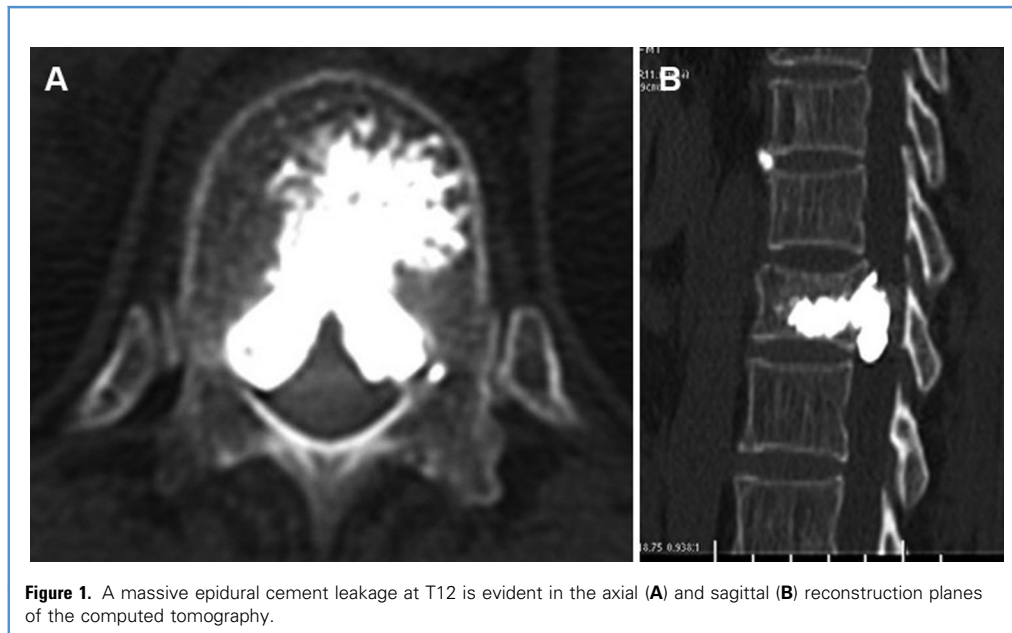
A massive epidural cement leakage at T12 is evident in the axial (A) and sagittal (B) reconstruction planes of the computed tomography.
